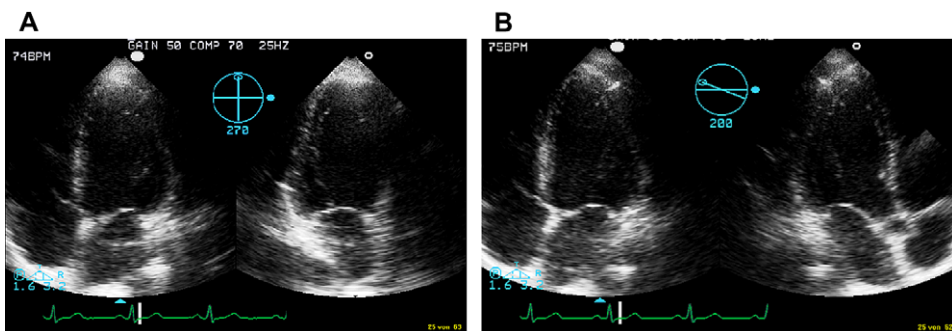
Biplanar stress echocardiography. Stop frame images demonstrate the image orientation from an apical echo window. Four-chamber view is always shown at the left side, on the right side in (A): two-chamber view, in (B): apical long axis.
